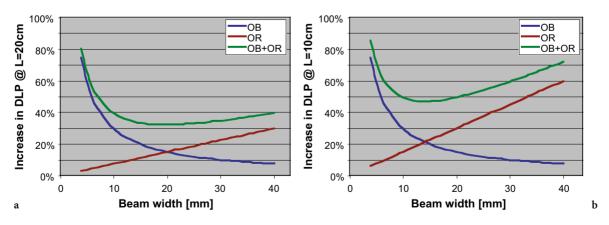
Increased dose-length product due to overbeaming (*OB*) and overranging (*OR*) effects for a typical multi-slice computed tomography (MSCT) scanner. For average to long scan ranges (L=20 cm and more, a), all beam-width settings above 10 mm perform almost equally well. For short scan ranges (L=10 cm, as in pediatric and spine exams, b), beam-width settings between 10 mm and 20 mm are preferred
